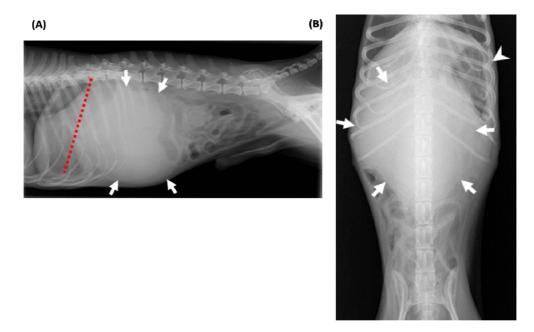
Abdominal radiographs of the mass. A soft tissue density mass $(10.2 \times 9.4 \text{ cm}; \text{ arrows})$ is located in middle abdomen. In the lateral view (A) the mass displaces the gastric axis (dotted line) cranially and the small intestine caudally. In the ventrodorsal view (B) the mass displaces the stomach body (arrow heads) to left abdominal wall.
